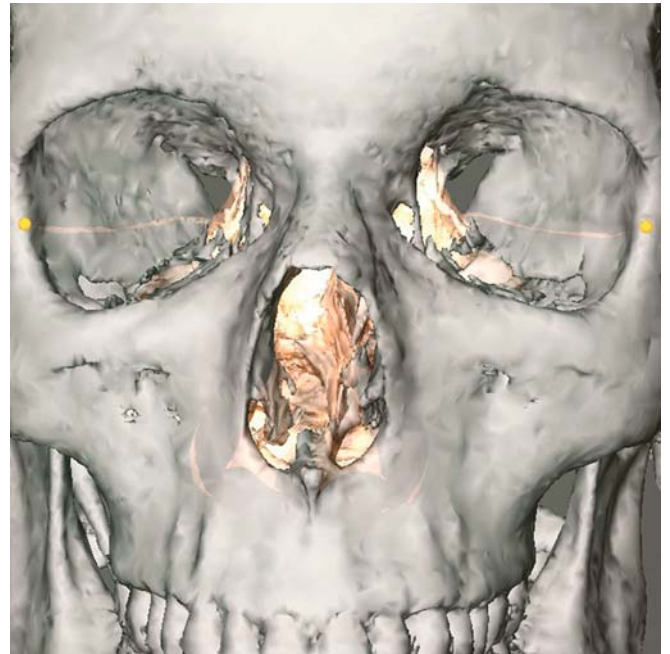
Exocanthion_r and exocanthion_l. Note that although the exocanthion landmarks are mostly located slightly medially from the lateral orbital rim, they can be projected onto the lateral orbital rim, especially if scanning was done with closed eyes. Frontal view (3-D CT, transparent soft tissues, patient K.C.)
